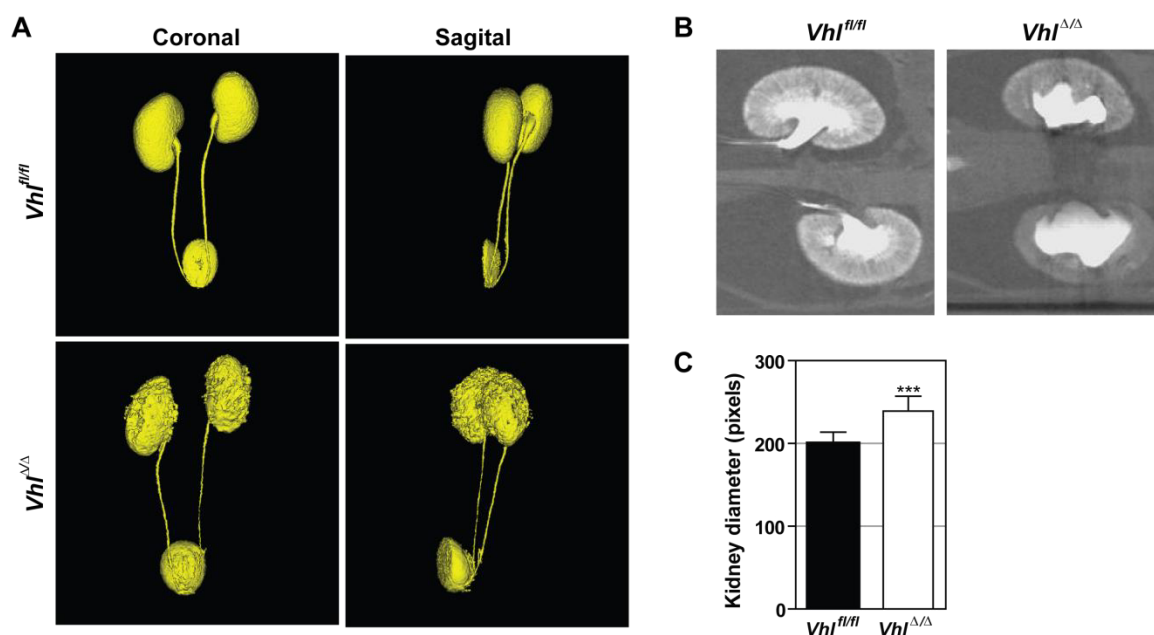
Hydronephrosis is not caused by kidney obstruction. (A) Three-dimensional reconstruction of kidney, ureter and bladder. (B) Coronal view of a two-dimensional image of control (*Vhl^{fl/fl}*) and *Vhl*-deficient kidneys (*Vhl^{Δ/Δ}*), (C) Measurement of kidney diameter *in vivo*. Caliper μ CT analysis. Contrast agent: Visipaque.
